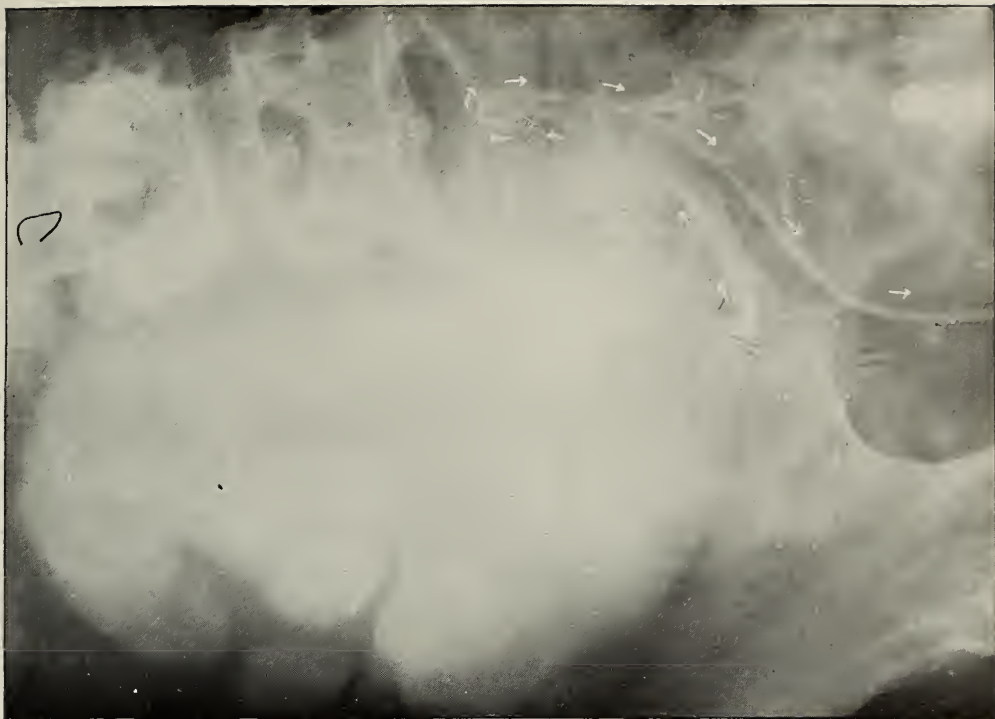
X-ray No. 10173 $\frac{1}{2}$ . Region: right lumbar. Huge hydronephrosis. Its position, outline and approximate size clearly demonstrated by colloidal silver. Note sharp bend in ureter indicated by arrow over spine. At operation found to be infected.
